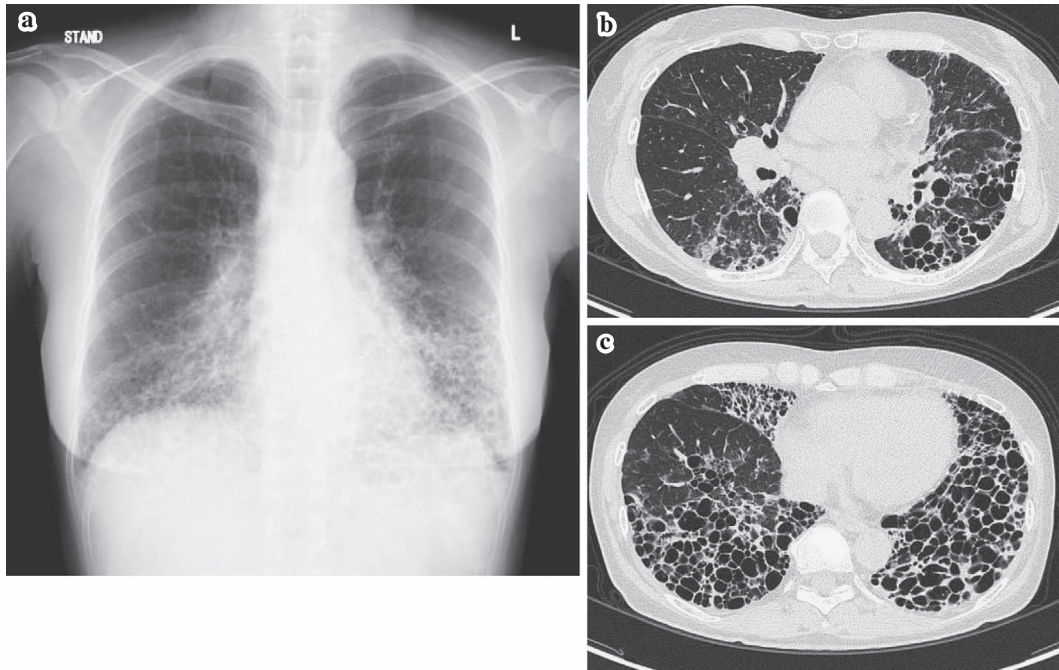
Radiological findings on admission. a) Chest radiograph showing severe cystic and reticular shadows in both the right and left lower lung fields. b) and c) Chest computed tomography scan images showing the honeycomb appearance of the lungs.
